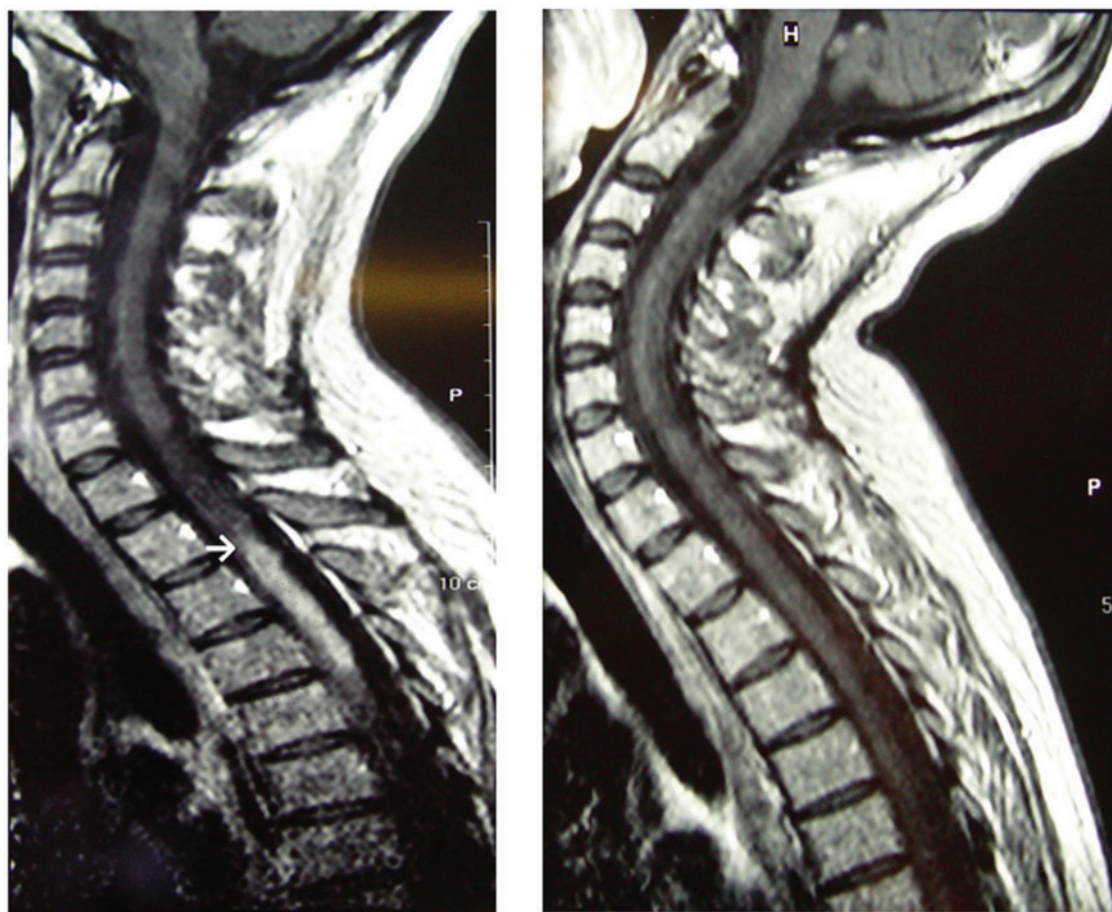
Magnetic resonance scan of the thoracic cord (sagittal T1-weighted images with gadolinium) showing the intramedullary enhanced lesion before (left image) and 1 month after treatment (right image).
